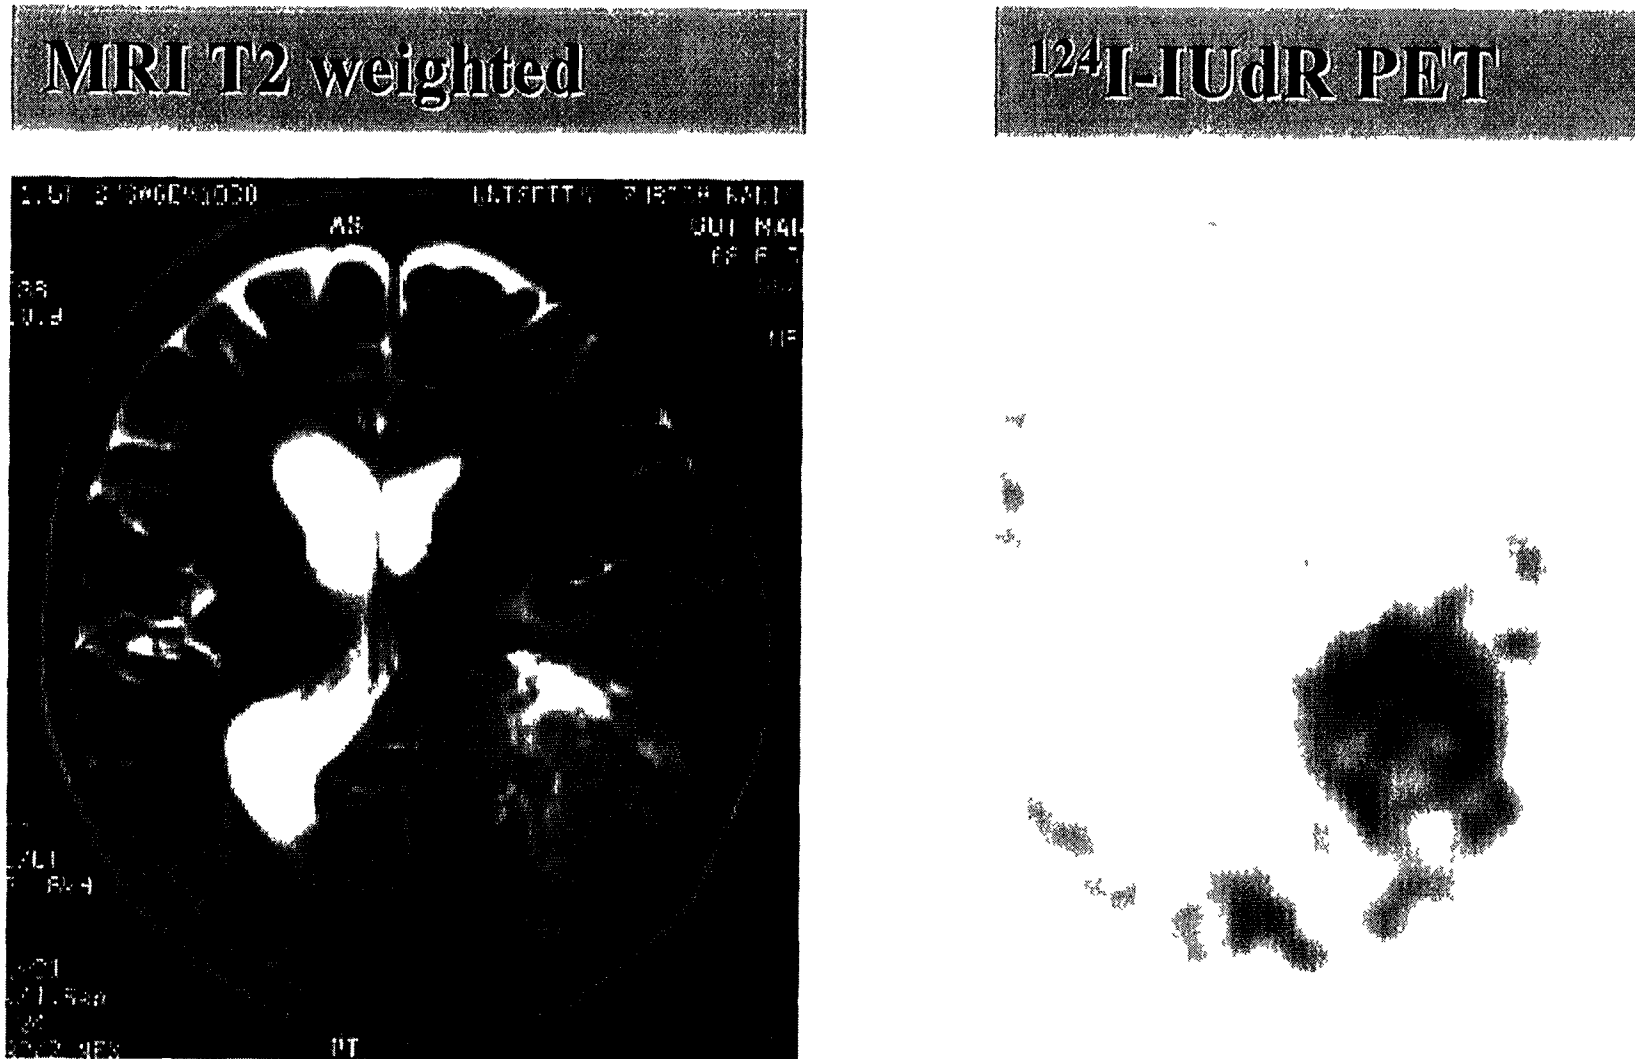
MRI and ^{124}I -IUdR PET scans of a Glioblastoma multiforme. The PET scan was taken 24 h after application and demonstrates the cell proliferation.
